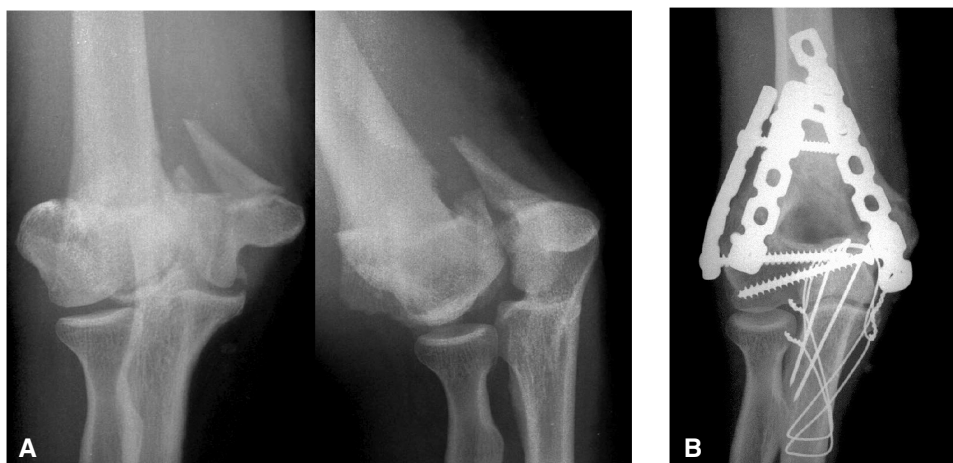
Extremely comminuted complex intraarticular fracture of the distal humerus in a 28-year-old male patient, sustained after a fall while snowboarding. A – Preoperative radiographs. B – Three months after triple plate fixation. Active ROM: extension–flexion arc 10–140°, supination 90°, pronation 90°. (Courtesy of Chaitanya S. Mudgal, MD)
